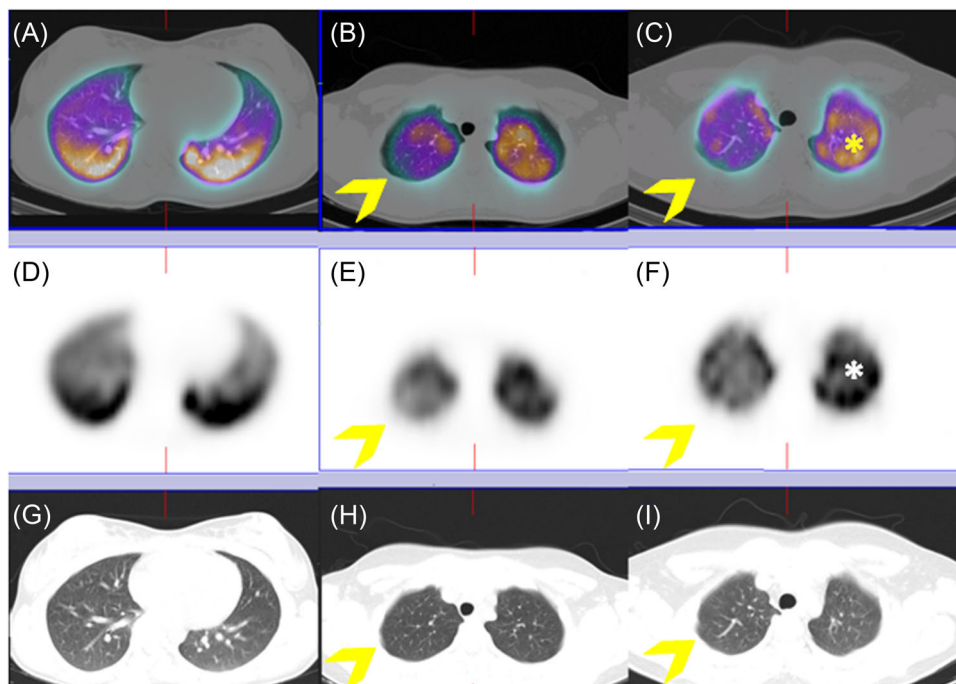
Lung SPECT/CT scan with ^{99m}Tc -MAA in three Long-COVID children. No significant lung perfusion alterations were detected in a patient with Long-COVID symptoms (A, D, F) on both axial hybrid images and functional slices (A, D). Conversely, MAA SPECT/CT showed an area of mild hypoperfusion in the apical segment of the right upper lobe, clearly evident on both axial fused and functional slices in another patients with Long-COVID syndrome (B, E; arrow). Lastly, an area of moderate hypoperfusion was detected on a third long COVID patient, clearly evident on hybrid imaging, as well as on the functional slices (C, F; arrow), which is associated to a diffuse and heterogenous distribution of radiopharmaceutical in both lung parenchyma (*). All these abnormal findings do not correspond to parenchymal alterations on co-registered CT images (G, H, I). MAA, macroaggregate albumin; SPECT/CT, single photon emission computed tomography with coregistered CT.
